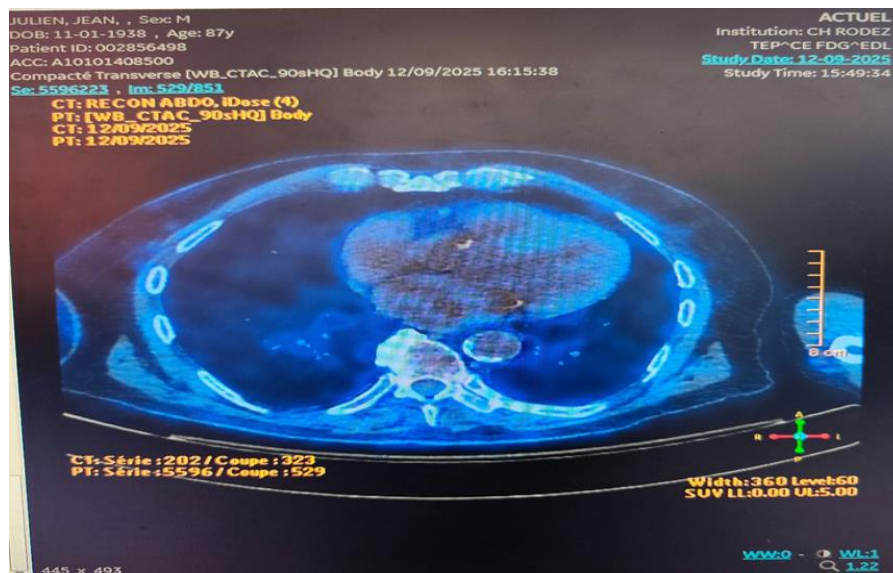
Whole-body 18F-FDG PET/CT demonstrating no abnormal FDG uptake within the right atrial mass, supporting the diagnosis of a benign cardiac lipoma
